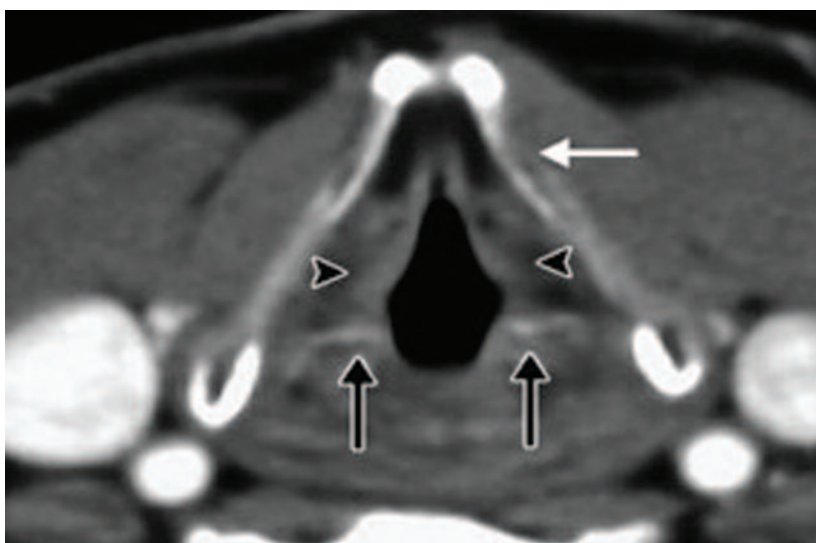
Post-operative neck computed tomography (CT) scan of the larynx after bilateral EAL. White arrow shows the output of the thread through the thyroid cartilage. Small black arrows show the laryngeal fold. Large black arrows indicate the lateralised arytenoid cartilage.
